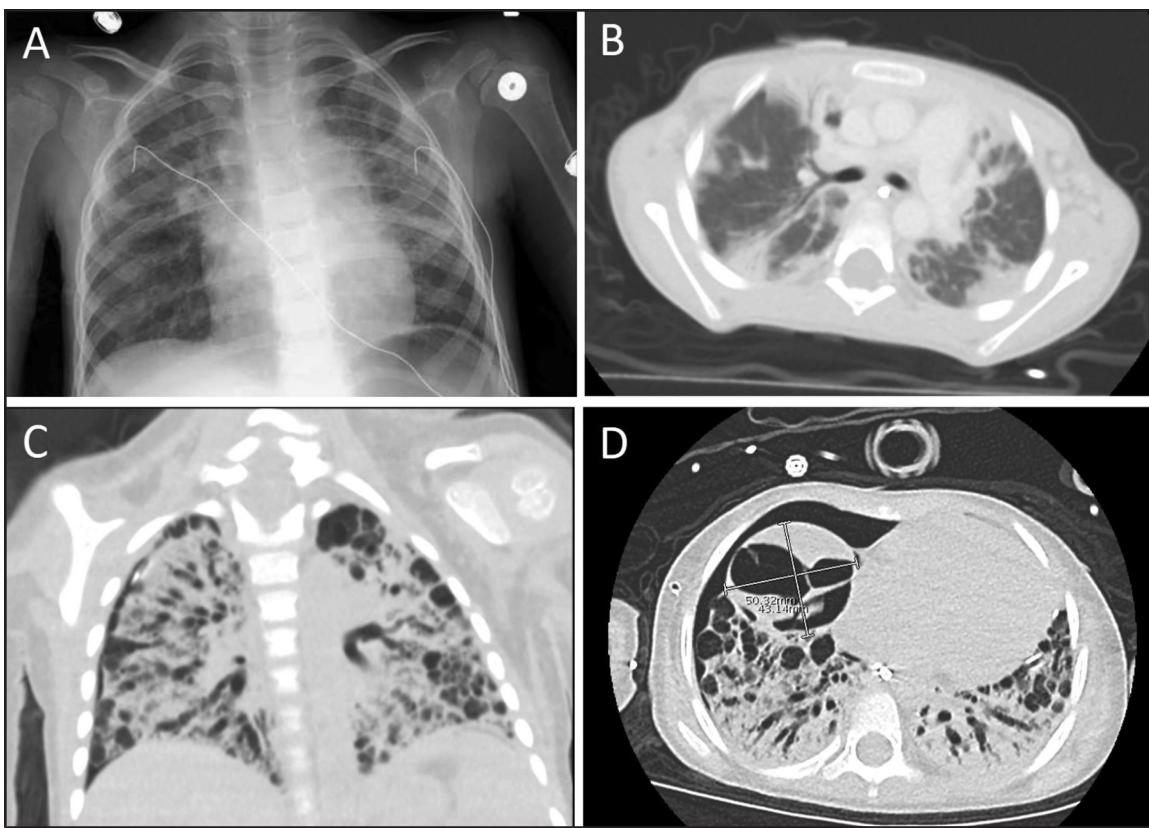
Progressing Radiographic Features of a Child with Organizing Pneumonia Associated with SARS-CoV-2 Infection
